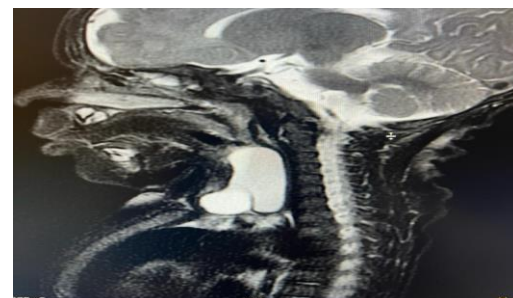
MRI of the neck post-intubation revealing an oblong-shaped, loculated cystic lesion involving
